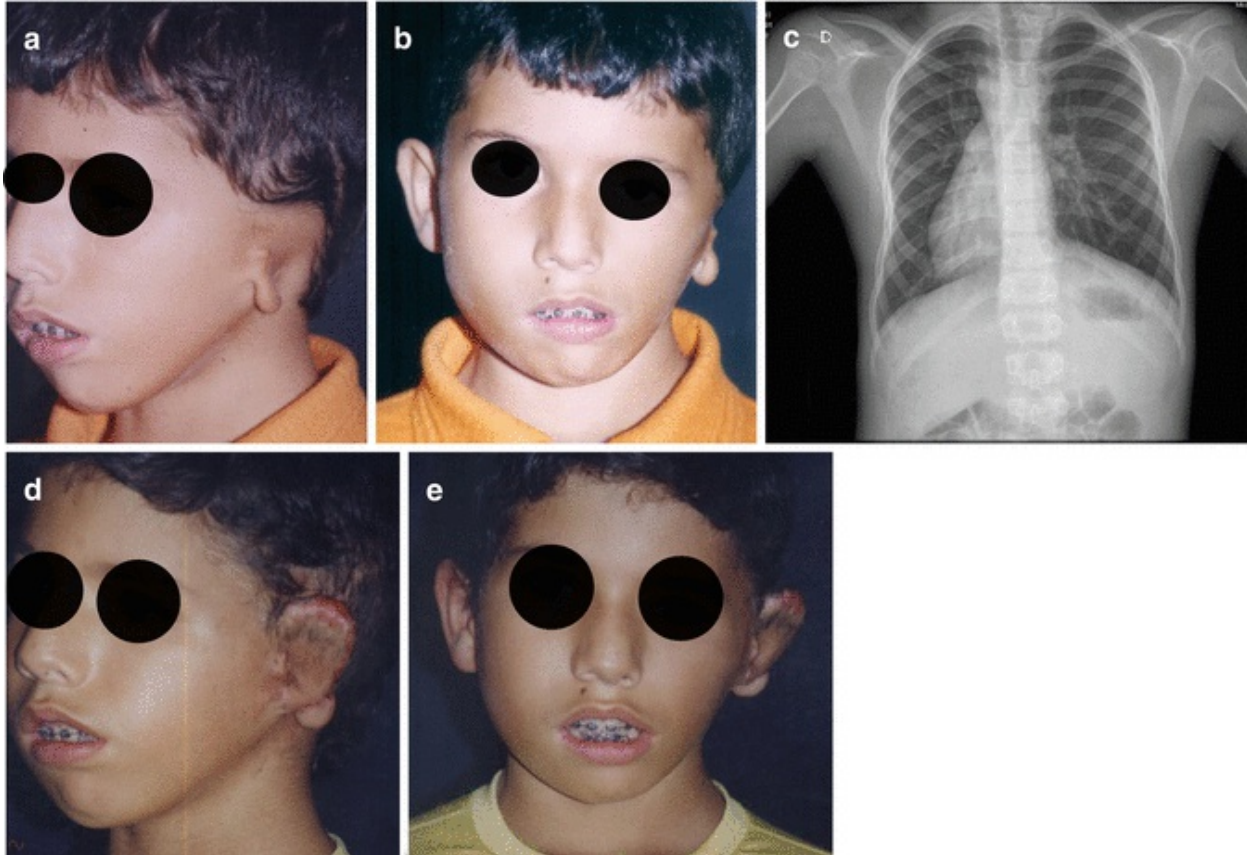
Anotia associated with several congenital anomalies: dextrocardia, deformities of chest wall, facial asymmetry, and disturbance of dental arcade. (a) Oblique view of an 8-year-old boy with anotia on left side; (b) photo of frontal view; (c) radiograph showing dextrocardia; (d, e) oblique view and frontal view after two surgical stages of ear reconstruction on the left side
